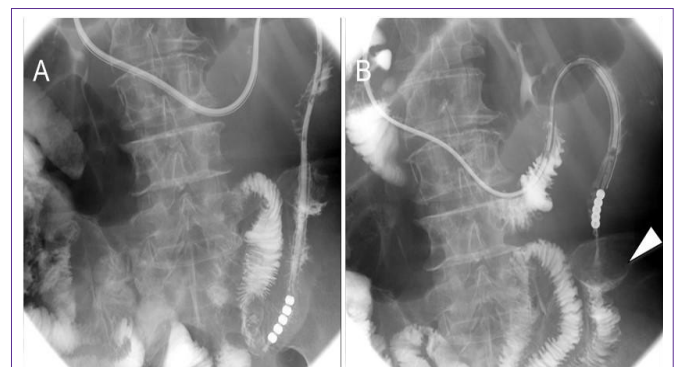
Contrast radiography of the intestine demonstrated Coiled spring sign (arrow) and a severe stenosis in the upper jejunum. The tip of long tube locates distal to the lesion (A) and intra-stenotic lesion (B).
